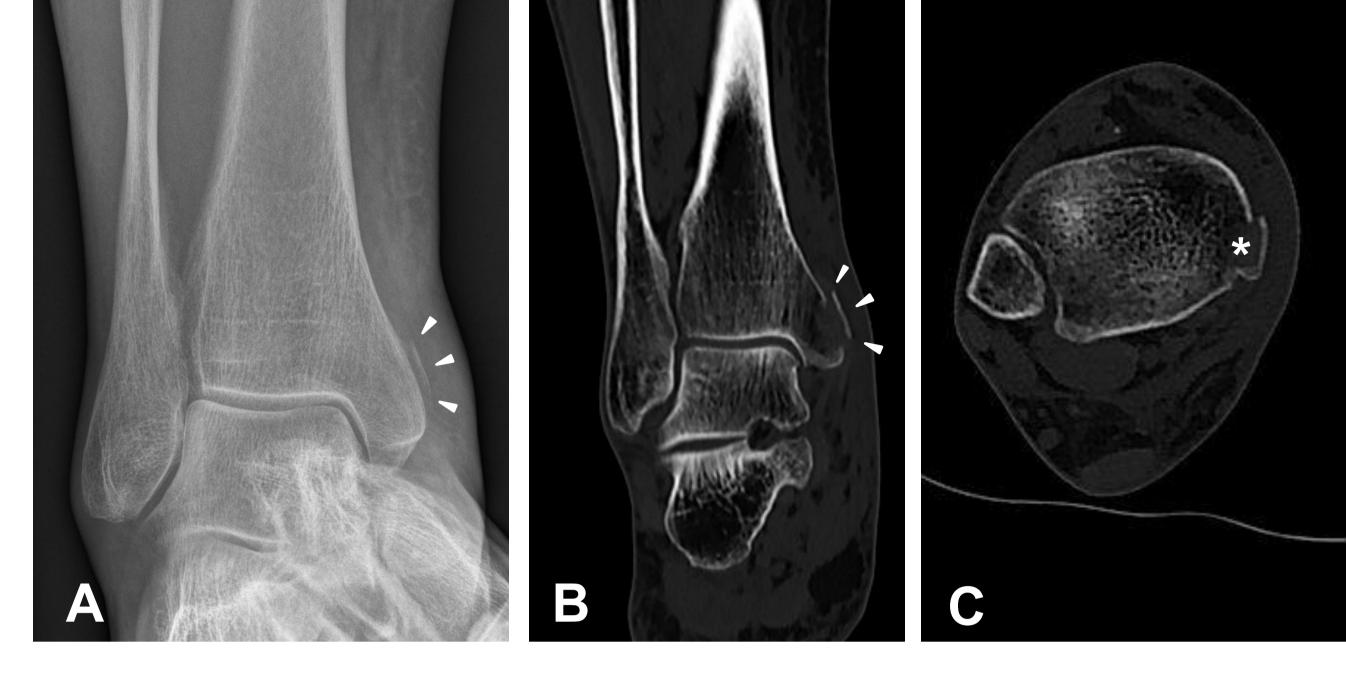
Anteroposterior radiograph of the right ankle showing an elevated cortical fragment proximal to the medial malleolus (1A). CT scan confirms the osseous avulsion (1B). On the axial plane the PTT can be identified underneath the fragment (1C *).
